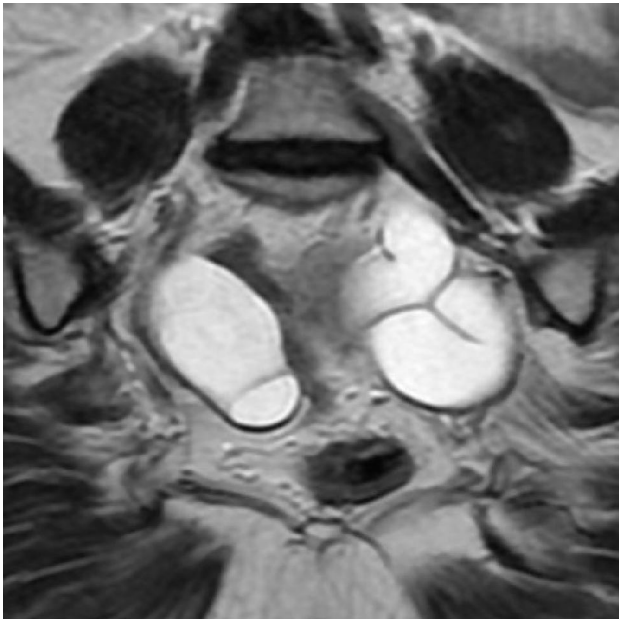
MRI T2 weighted Coronal Image: Dilated tubular fluid signal intensity convoluted structures are seen in both adnexa representing Hydrosalpinx.
